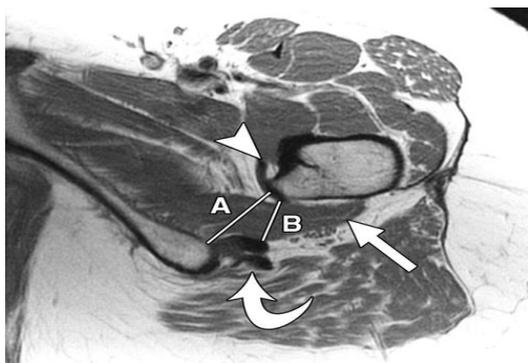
Diagnosis by magnetic resonance image ⁵
